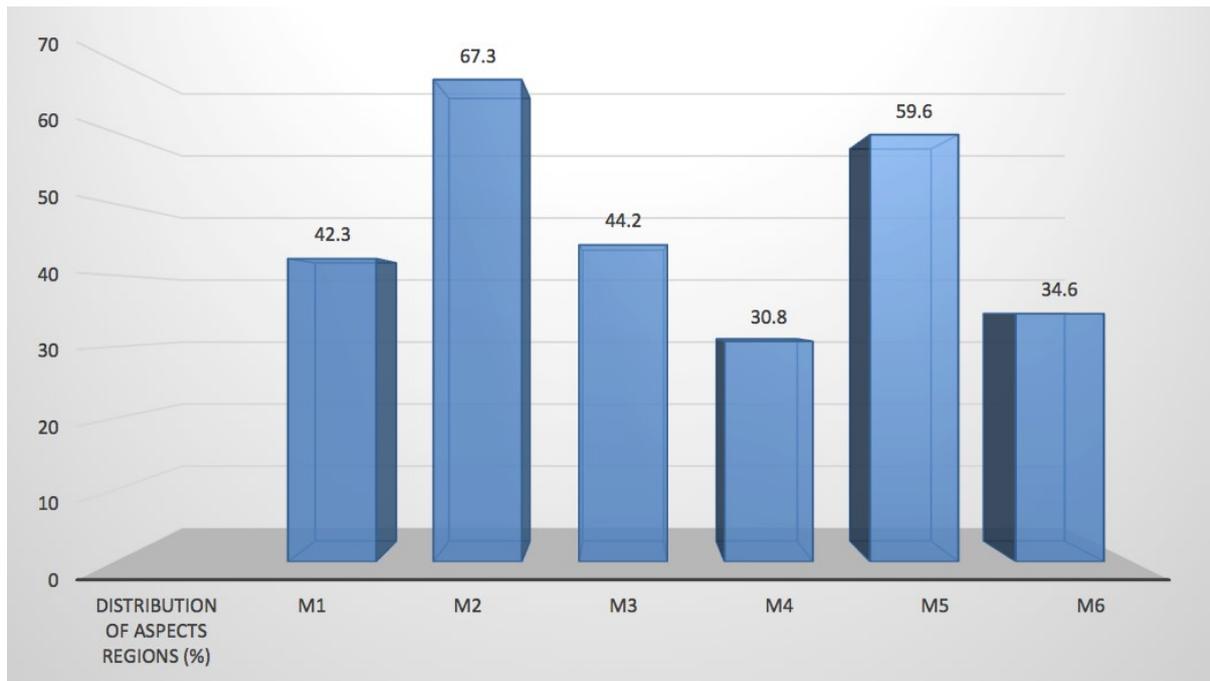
Distribution of ASPECTS regions by %. M2 and M5 were more affected than the other areas.
